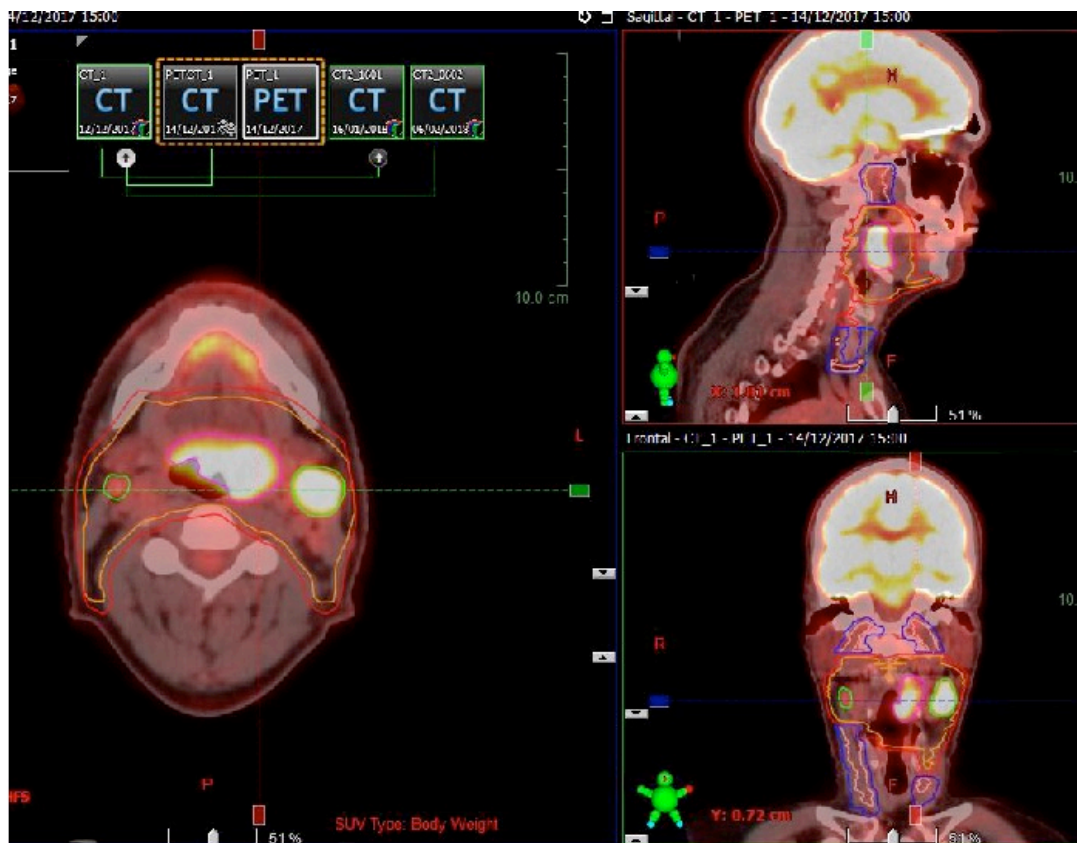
Definition of target volumes with PET/CT-visual assessment. GTV_T (magenta) and GTV_N (green) with an isotropic margin of 15mm and 10mm respectively, and the corresponding high risk nodal levels were included in CTV65 (orange) with correction for airways and anatomical barriers. CTV65 was expanded with a 3mm margin to generate PTV65 (red). Low risk nodal levels were included in CTV54 (pink) with a margin of 3mm for PTV54 (blue).
